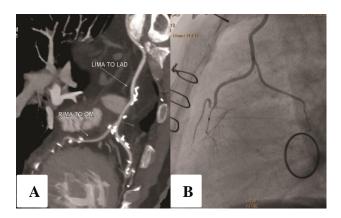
Patent LIMA to LAD with Sequential Ygraft of RIMA from LIMA to OM graft, (A): MPR image of CT, (B): Corresponding catheter angiography image.
